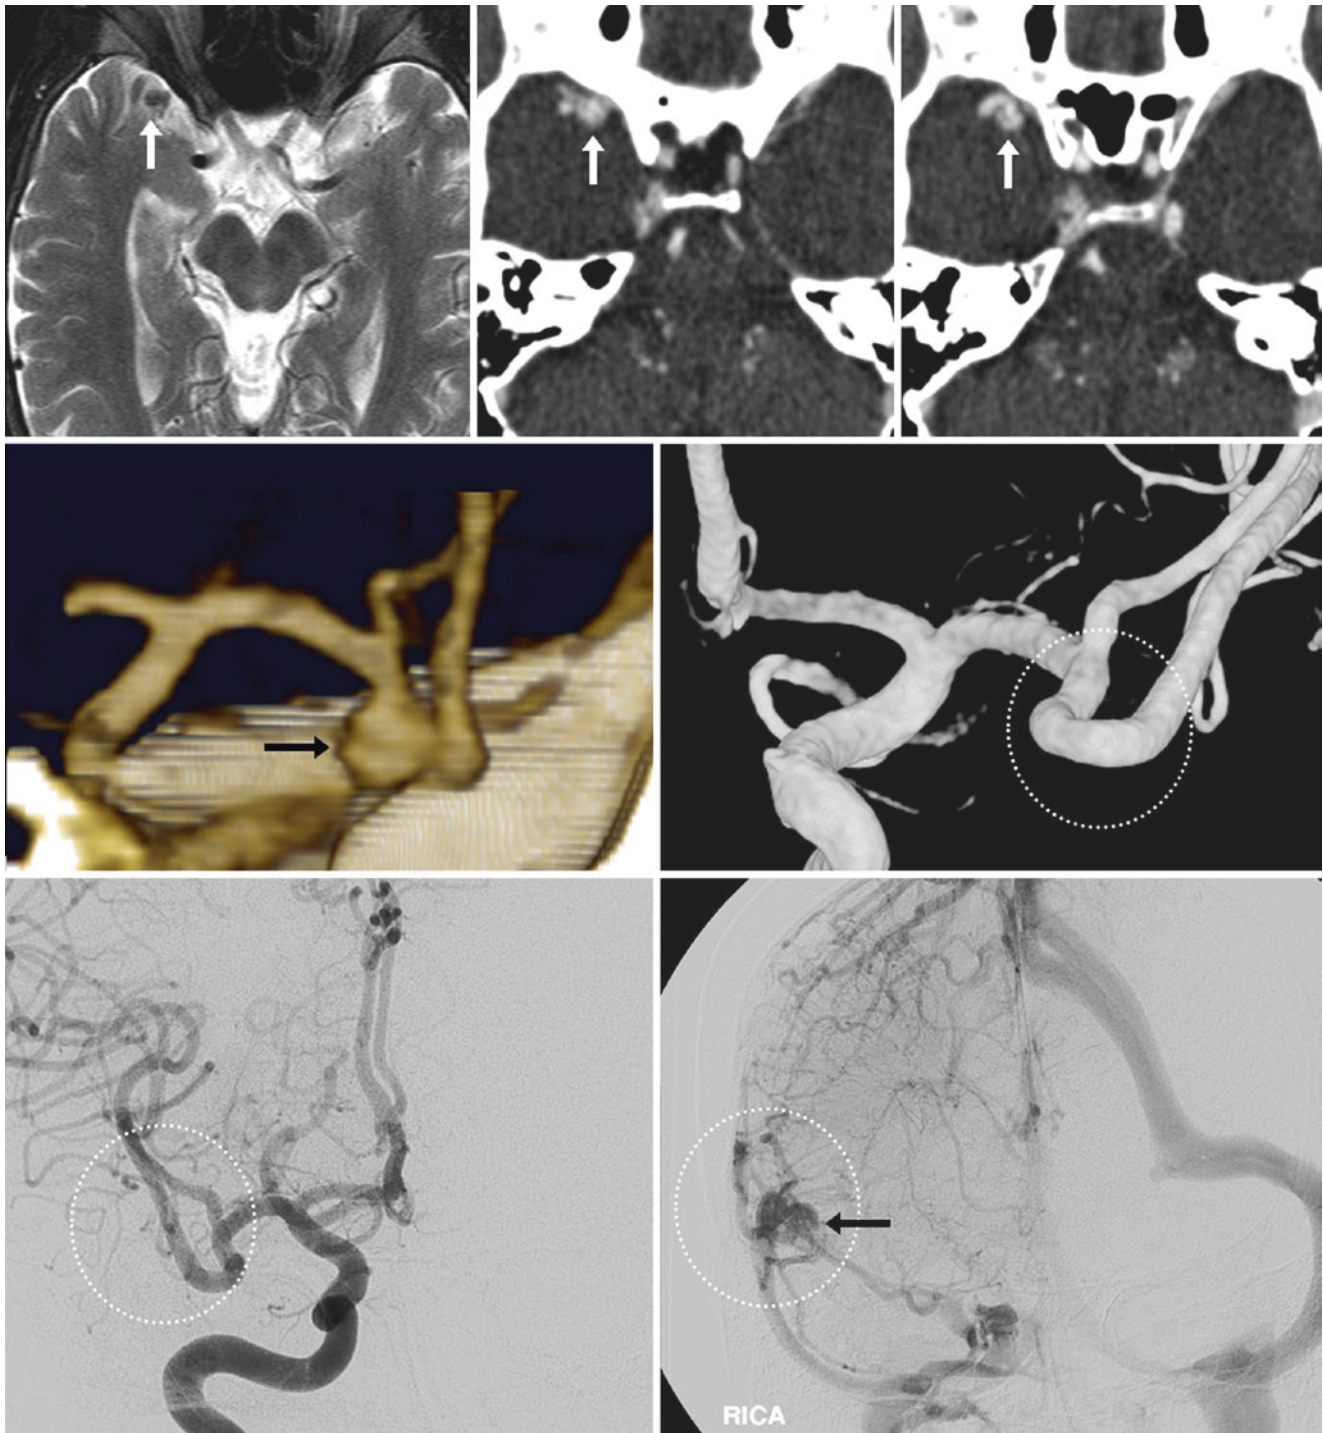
38-year-old with confusion. *Top row:* A focal bulbus vessel (arrows) was noted in the vicinity of the right MCA on axial T2WI (left) and source CTA images (middle and right), raising the possibility of an aneurysm. *Middle row:* A 3D VR CTA PA view (left) showed that this was adjacent to an inferior division M1-2 branch (thin arrows), but at this point it was considered indeterminate whether the bulbus structure was arterial or venous in nature. Catheter 3DDSA images did not
